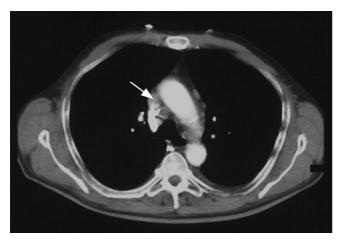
CT scan of chest showing enlarged para-aortic lymph node.
